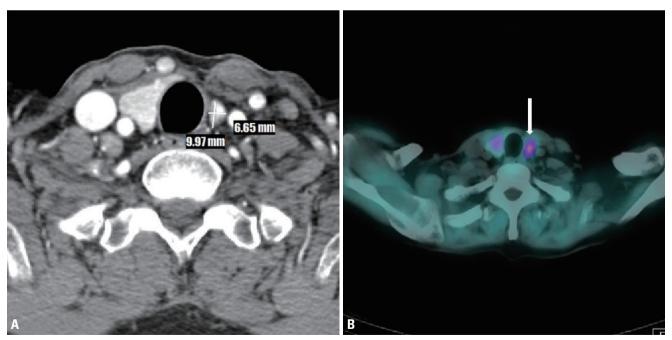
(A) Thyroid computed tomography shows a $12 \times 9.97 \times 6.65$ mm enhanced nodule at the posterior aspect of the left thyroid lower pole. (B) Parathyroid metaiodobenzylguanidine scan shows a 1.3-cm soft-tisssue lesion with increased uptake of the radioactive tracer at the lower pole of the left thyroid gland (white arrow).
